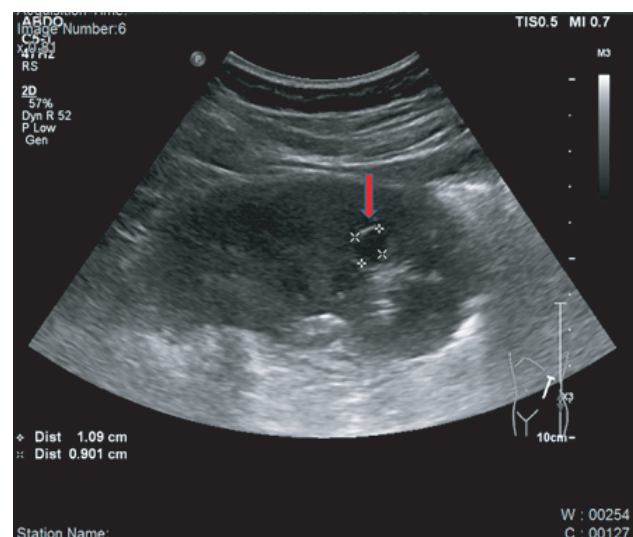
Ultrasound image of the left kidney pre-biopsy. There was a renal cyst (red arrow) measuring 1.09cm x 0.90 cm, located at the lower pole of the left kidney.
